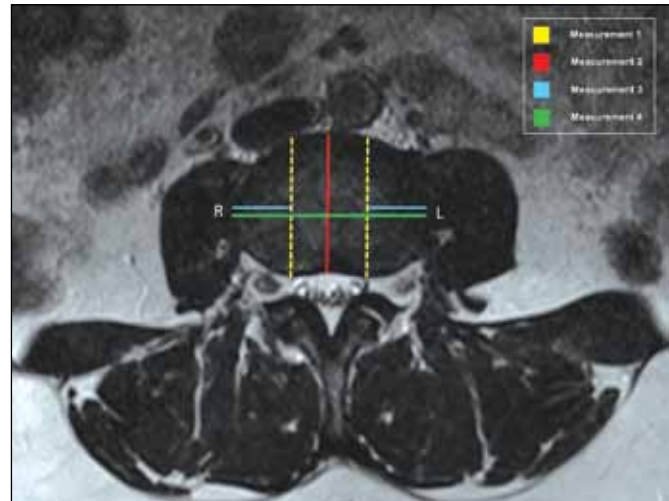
Measurements of lumbar disc are shown on the axial T2W MRI scan.
